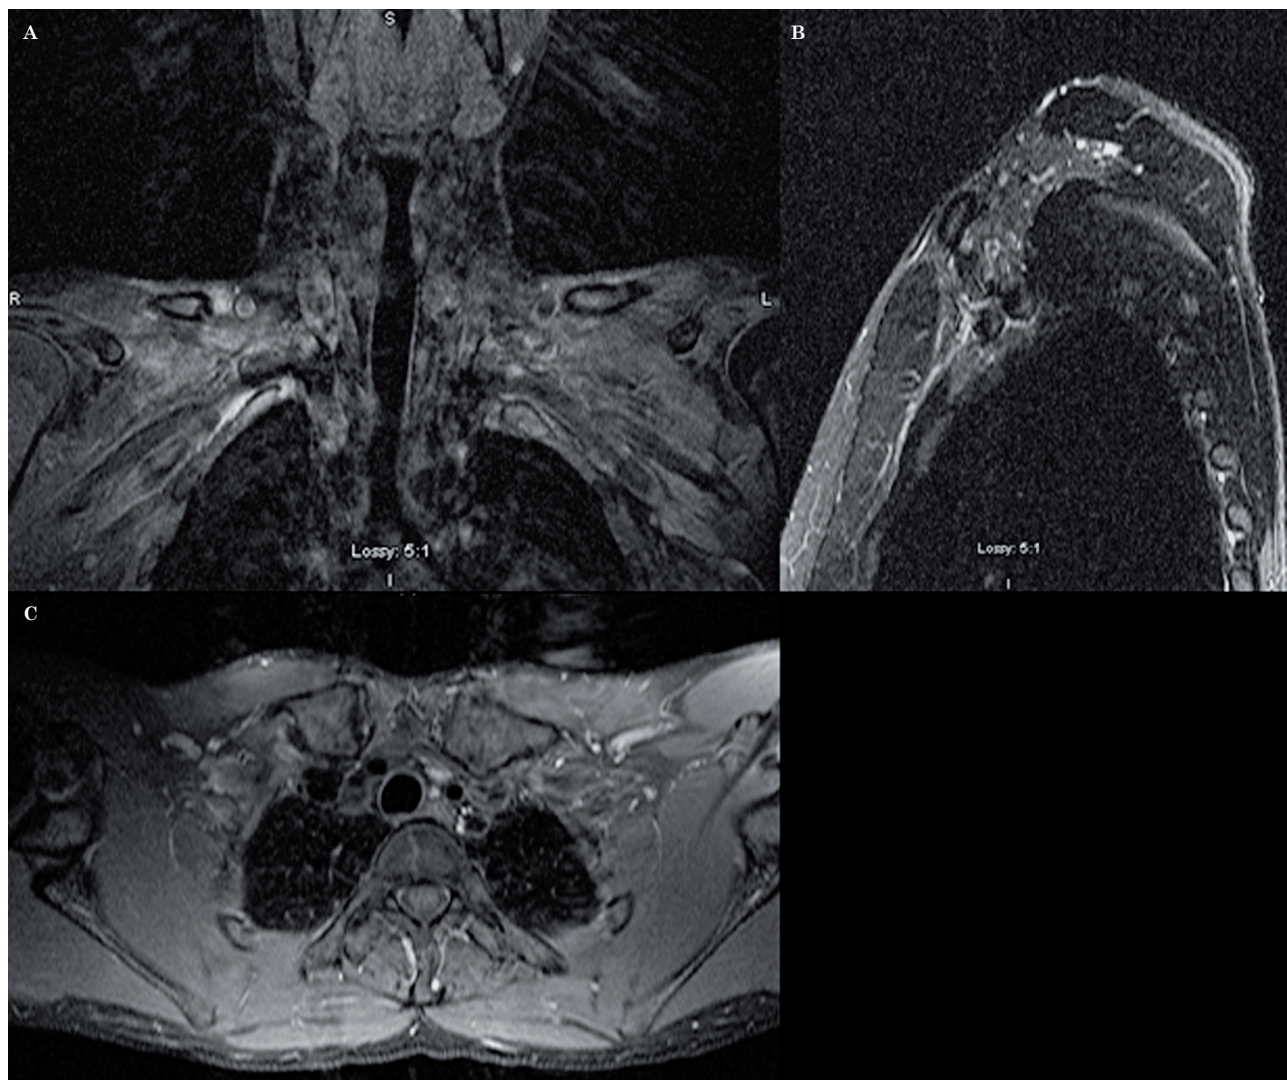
MRI of the left brachial plexus using the Conventional technique, in 2005, for the study of ulnar neuropathy. Coronal T1-weighted sequence post-contrast with fat saturation (A), sagittal STIR (B) and axial T1-weighted sequence post-contrast with fat saturation (C). No abnormality was identified.
